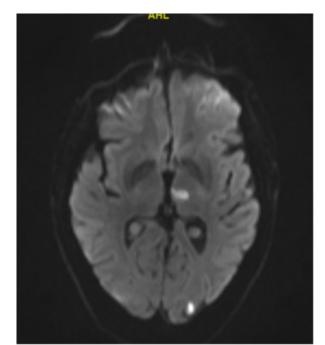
of MRI brain shows the left thalamic and occipital lobe strokes
